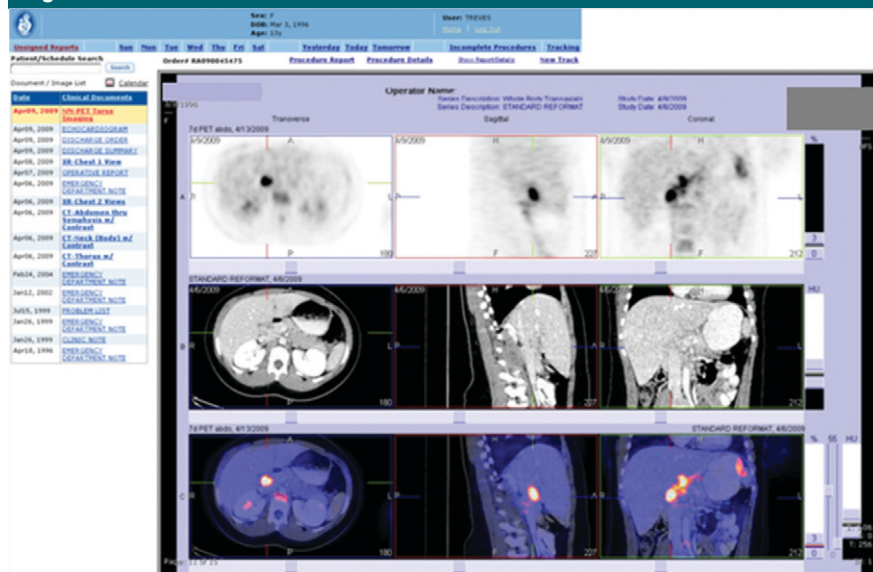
Screenshot of nuclear medicine viewer shows PET (top), CT (middle), and fused PET/CT (bottom) images.
